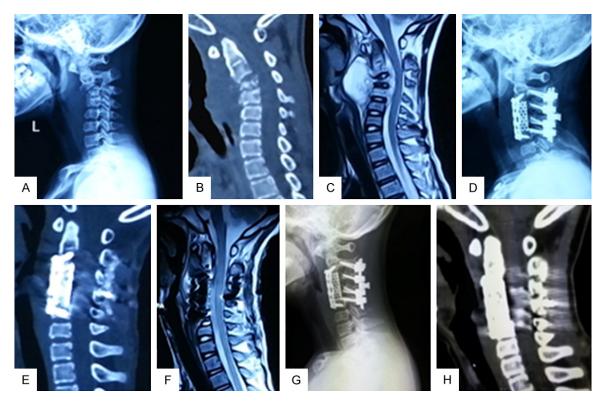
A 10-year-old male child, suffering from tuberculosis of C3-4 complicated with kyphosis. A-C. Preoperative X-ray films, CT and MRI revealed destruction and collapse of vertebral bodies, narrowing of intervertebral-disc space, kyphotic angle of 29°, epidural and paravertebral abscess, compression of cervical cord, and Frankel's grade D. D-F. Postoperative X-ray films, CT and MRI revealed thorough debridement, decompression and recovery of spinal canal volume, kyphotic angle of -7°, and Frankel's grade E. G, H. At 36 months after surgery, X-ray films and CT revealed bone graft fusion, kyphotic angle of -6°, Frankel's grade E, and no complications related to instrumentation and recurrence of tuberculosis.
